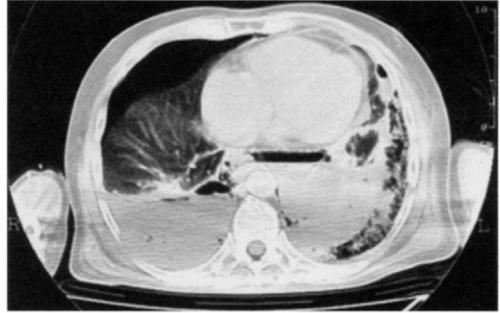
Axial CT. Air-fluid levels within mediastinum. Extensive pleural effusions.
